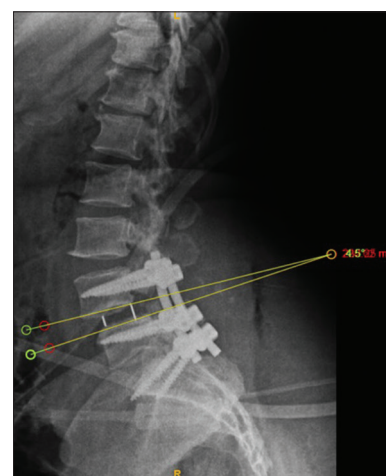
Post-operative lateral radiograph showing measurement of residual translation of L4 over L5, length of L5 vertebral body
